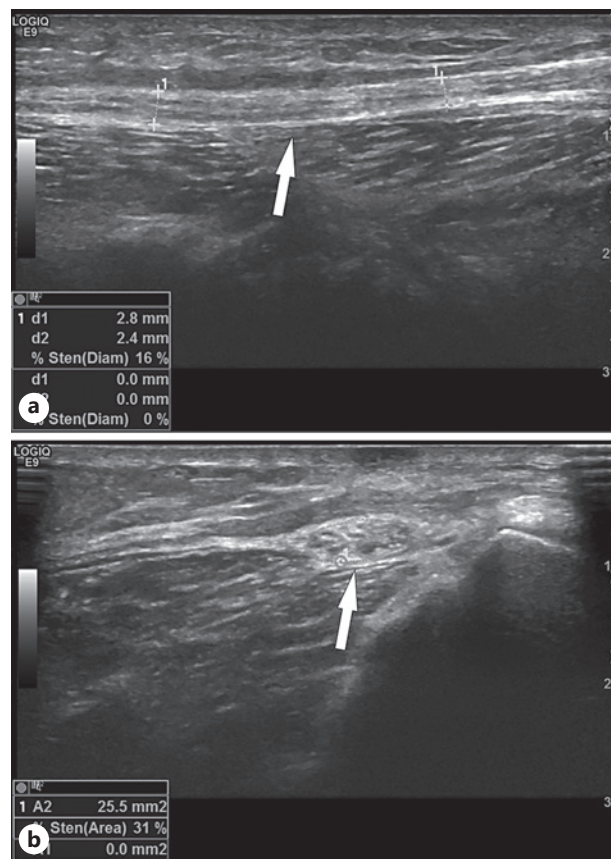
Postoperative ultrasound images of the peroneal nerve at the resection site. a Ultrasound image showing a longitudinal cross-section of the nerve (marked with white arrow). b Parallel ultrasound slice of the nerve showing increased intraneural echogenicity.
